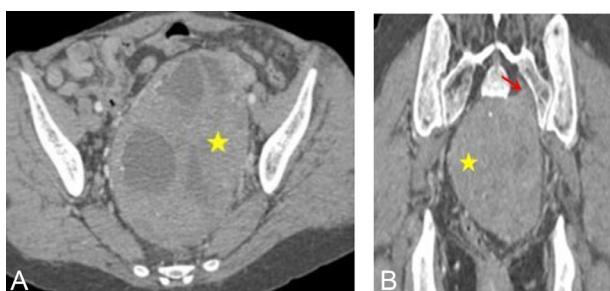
Contrast-enhanced computed tomography in axial (A) and coronal (B) sections showing a large solid-cystic mass (★) arising from sacrococcygeal region which appears to impinge on the left first sacral foramen (red arrow).
